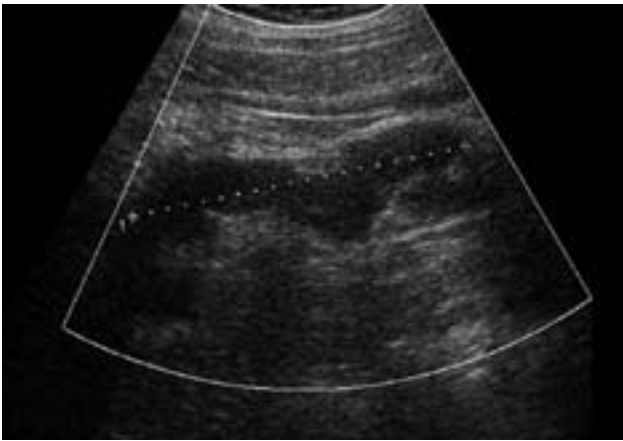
Preoperative ultrasound showing the tubular structure (day 12 post-delivery)
